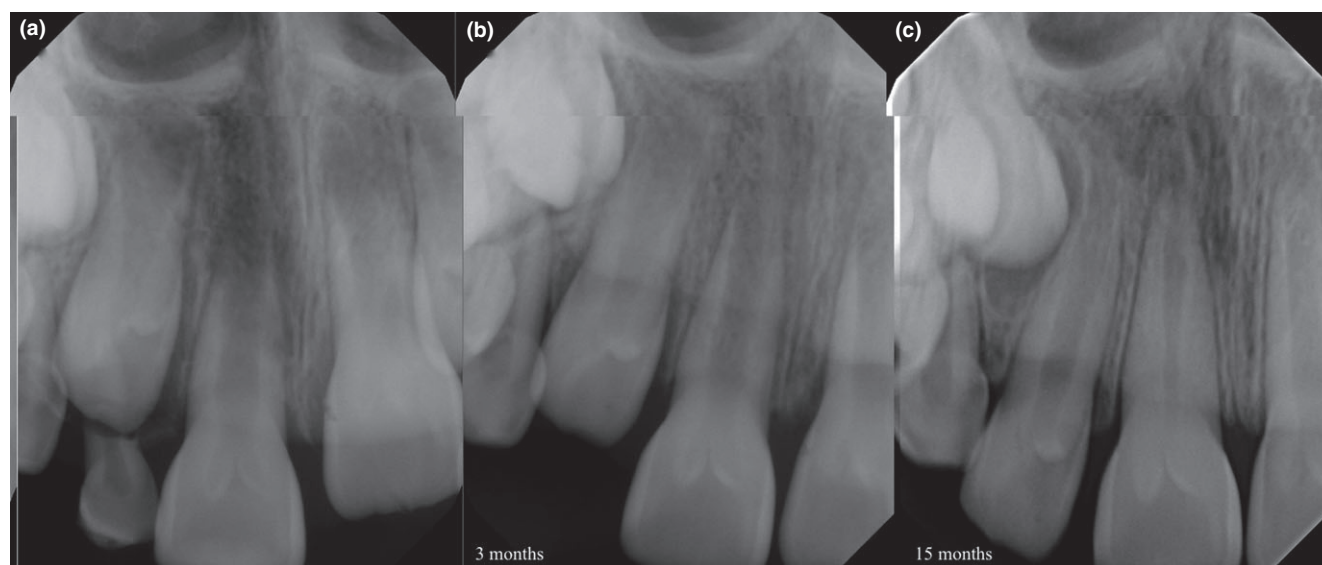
Radiographs taken immediately after trauma (a), 3 months (b) and 15 months (c) follow-ups. The upper right central incisor did not respond to pulp sensibility testing but evidence of continued root development indicates pulp revascularization.
